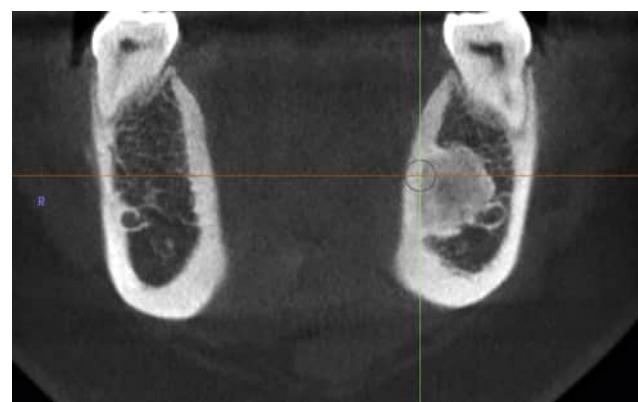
CBCT, coronal view (same patient to this, Fig. 5.14). Notice also no expansion.
